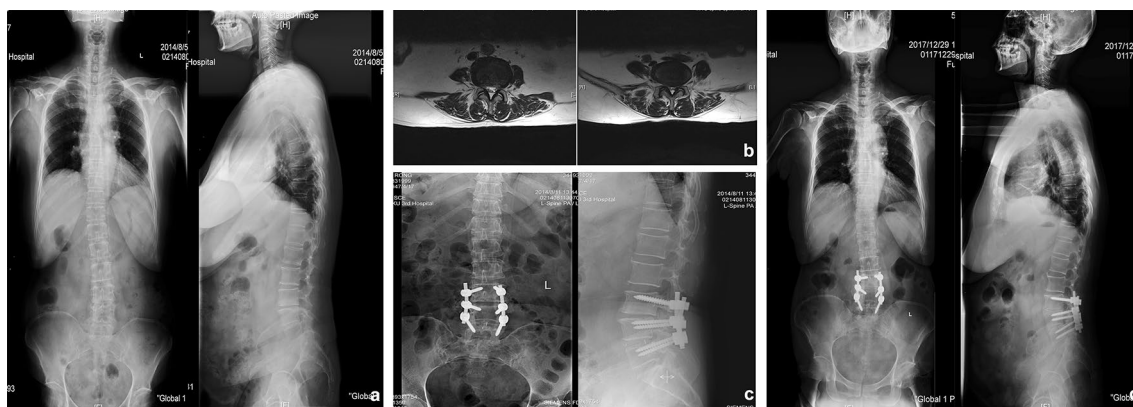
A 67-year-old woman classified as type II. a The standing long-cassette anteroposterior and lateral radiographs of spine demonstrating a Cobb angle of 14.9° and L3/L4 as the apical vertebra with a balanced spine. b Axial T2-weighted magnetic resonance imaging
